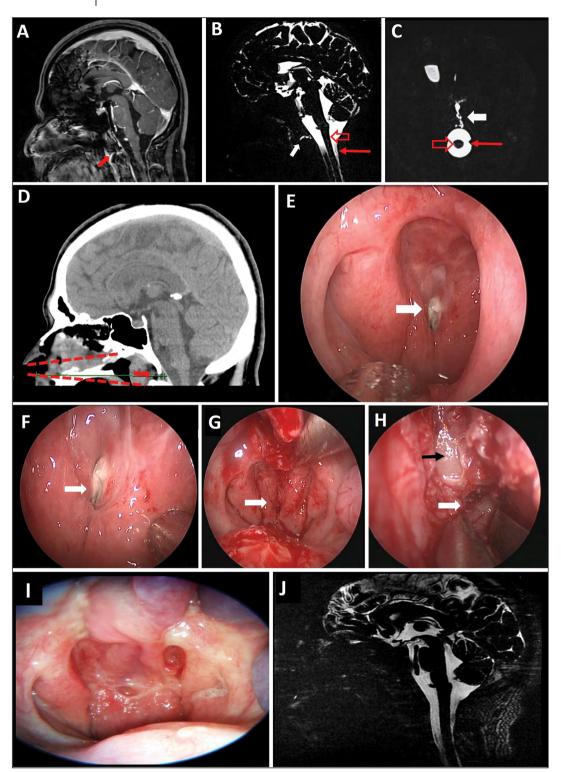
A. Sagittal T2 MRI showing CSF fistula (red arrow). B. Preoperative sagittal MRI cisternography showing CSF fistula (white arrow), spinal canal (solid arrow) and spinal cord (transparent arrow). C. Preoperative axial MRI cisternography showing CSF fistula (white arrow), Spinal canal (solid arrow) and spinal cord (transparent arrow). D. Sagittal CT showing probable SMD probe trajectory. E. Endoscopic view of fistulous tract (white arrow). F. Fistulous tract during Valsalva maneuver with resultant CSF gush (white arrow). G. Image after posterior septectomy and raising a nasoseptal flap. H. Midline nasopharngeal tissue dissection revealing the lower clivus (black arrow) and the fistula (white arrow) seen off the midline to the left at the craniocervical junction. I, J. Postoperative endoscopic and MRI images showing resolution of the fistula tract and complete healing of the nasoseptal flap.
